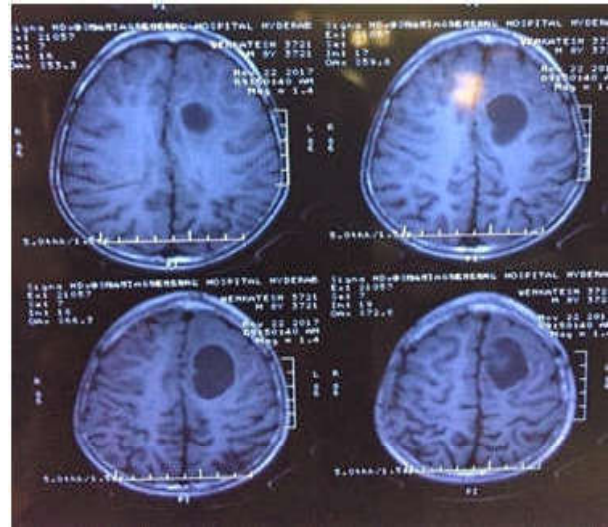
A plain MRI of brain showing well defined solid-cystic lesion in left frontal cortex
